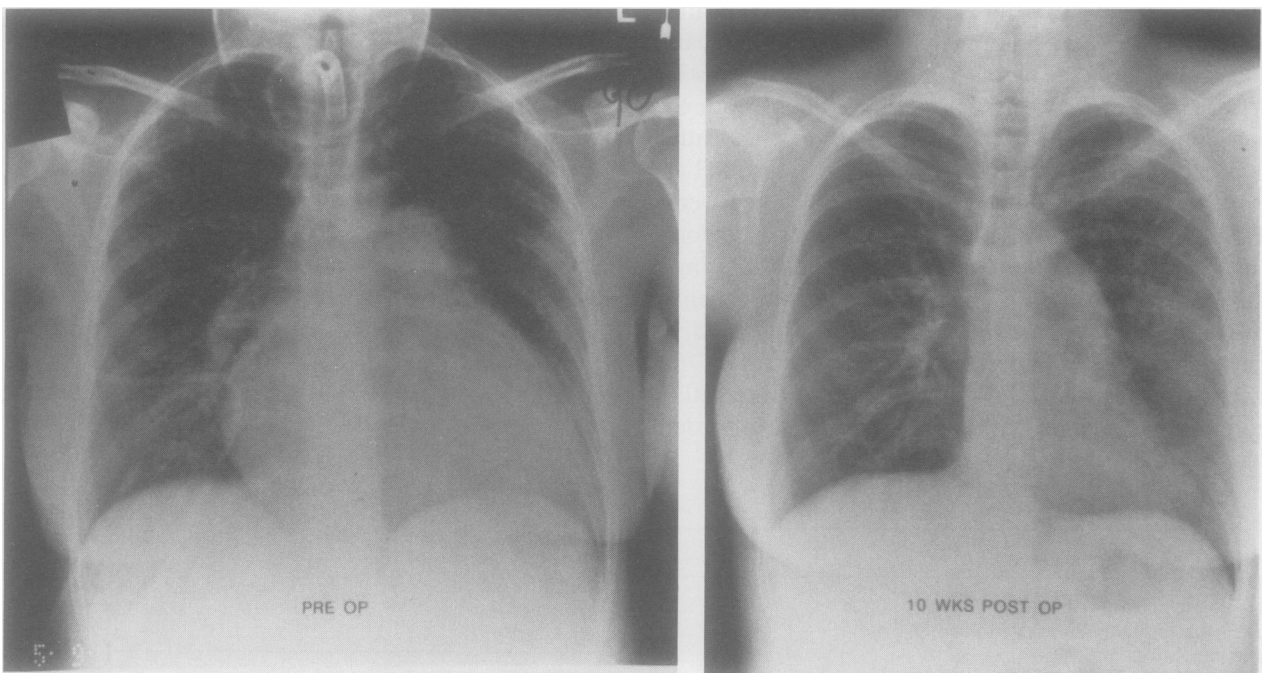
Chest x-rays of a 27-year-old woman who received a right single lung transplant for primary pulmonary hypertension. Left, preoperative; right, 10 weeks postoperative.
